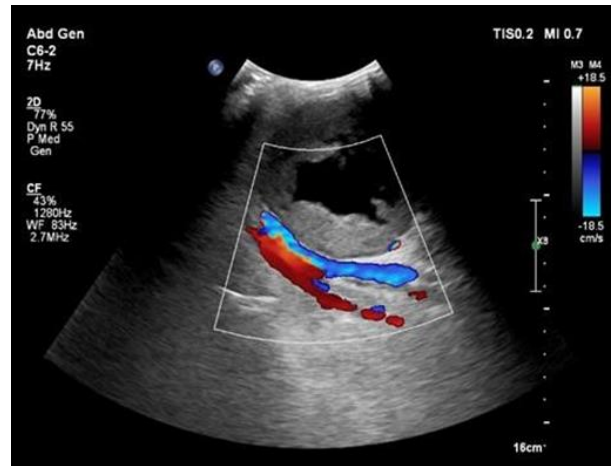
Ultrasound image showing relation to femoral vessels
